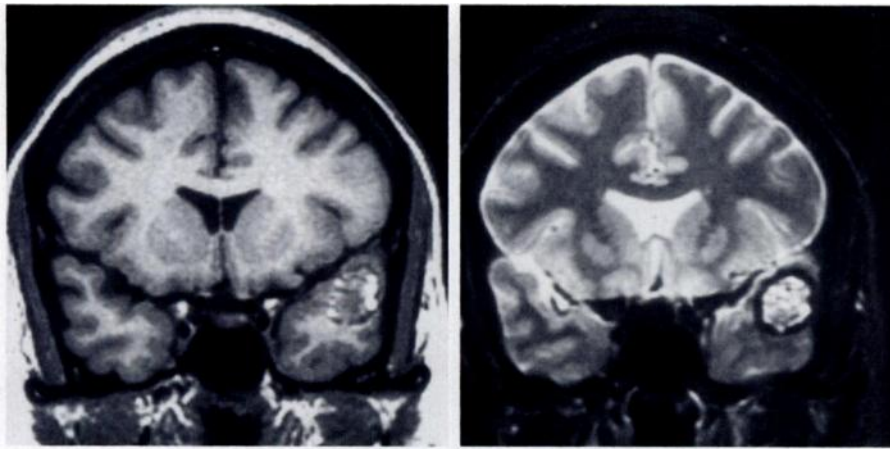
Capillary hemangioma in a 47-year-old woman with partial complex seizures of the left temporal origin since age 43 years. The patient has been seizure-free for 3 years following surgery. (a) T1-weighted and (b) T2-weighted MR images demonstrate typical features of a capillary or cavernous angioma. These are an outer rim of hemosiderin or ferritin deposition, which displays decreased signal intensity on T1-weighted images and to a much greater extent on T2-weighted images. A nonhomogeneous central portion is hyper- to isointense on T1-weighted images and hyper- to hypointense on T2-weighted images.
